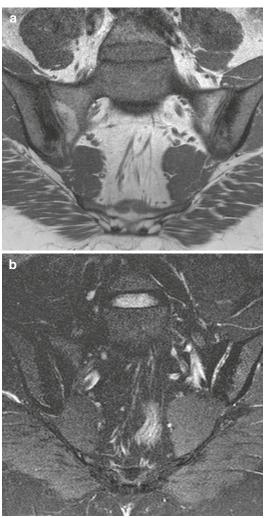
MRI SIJ in a 24-year-old female, HLA positive, (a) Cor T1 and (b) Cor T2FS demonstrate bilateral post-inflammatory fat accentuation (PIFA) and subchondral sclerosis on the sacral and iliac aspect, respectively. Note the fat is high signal on T1 and becomes low signal on T2FS, whereas the subchondral sclerosis remains low signal on all sequences
